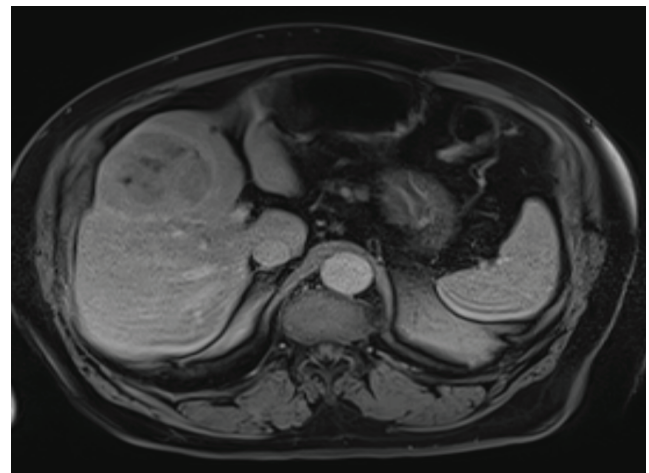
MRI before Transcatheter arterial chemoembolization (TACE)
